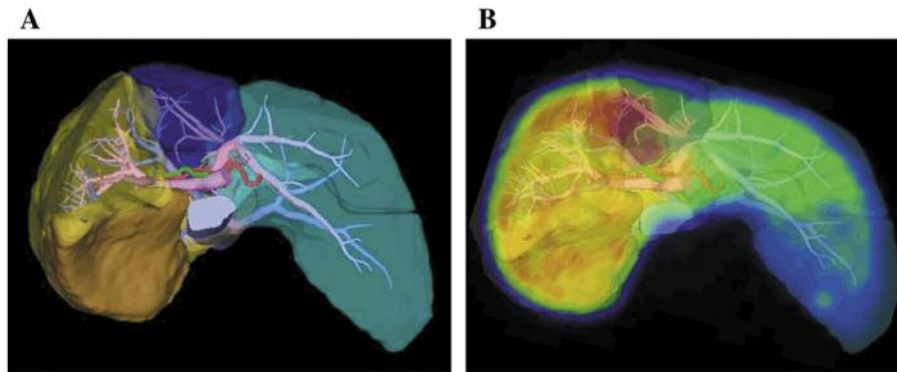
Each liver section (left lateral, medial, right anterior, right posterior) was extracted from multidetector computed tomography (MDCT) three-dimensional volumetry (A) and MDCT/<sup>99m</sup>Tc-galactosyl albumin single-photon-emission computed tomography fusion imaging (B).
